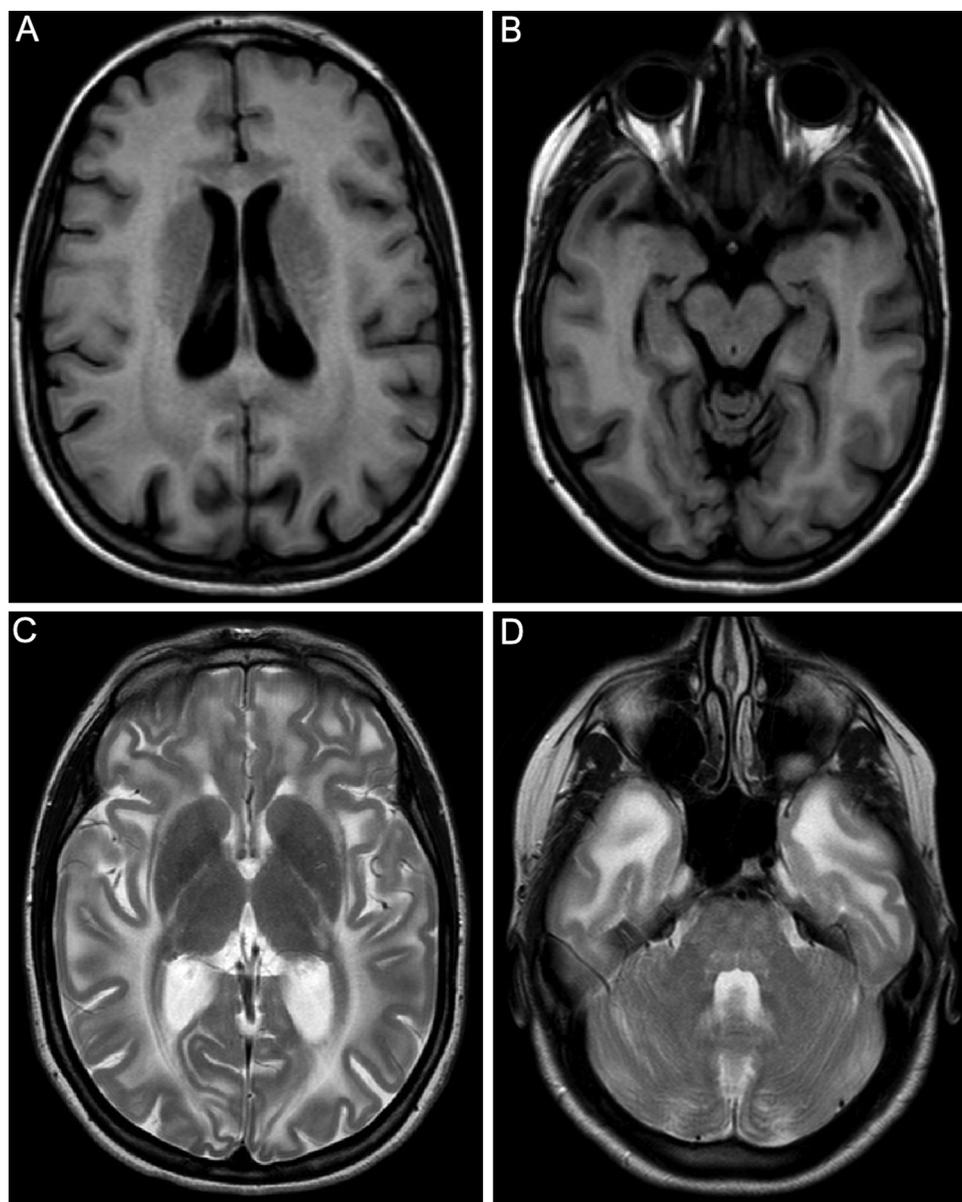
Brain magnetic resonance imaging findings: axial view of fluid-attenuated inversion-recovery (FLAIR) sequence shows diffusely abnormal and mildly edematous white matter (A) and bilateral anterior temporal cysts (B); axial T2 weighted images demonstrate a double-line-shaped abnormal signal in the posterior limb of the internal capsule (C) and a mildly increased signal from the cerebellar white matter (D).
